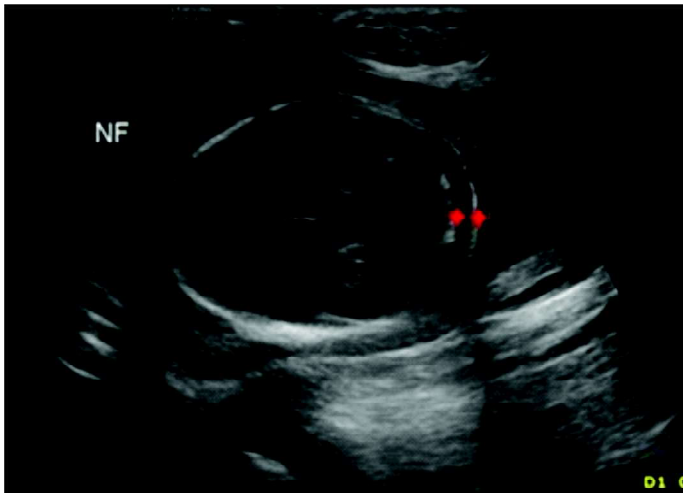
2 D gray scale ultrasound image of fetal head in trans cerebellar plane showing the correct method of measuring the nuchal fold. It is measured from outer edge of skin to outer edge of bone.
